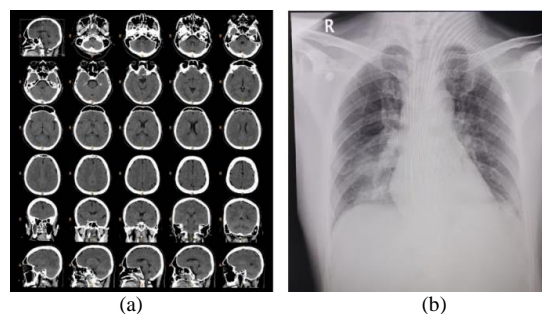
Examination result on patients: (a) CT scans; (b) Chest X-ray
